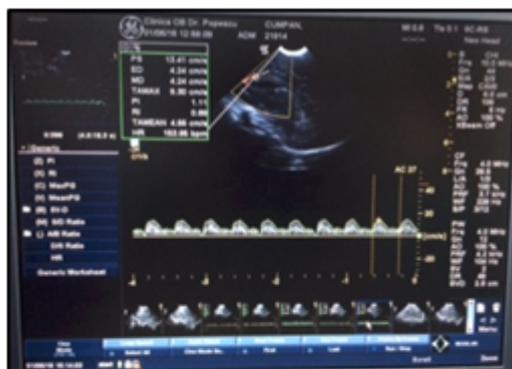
RI to anterior cerebral artery/pericalosal artery using cerebral ultrasound in the first 7 days of life
